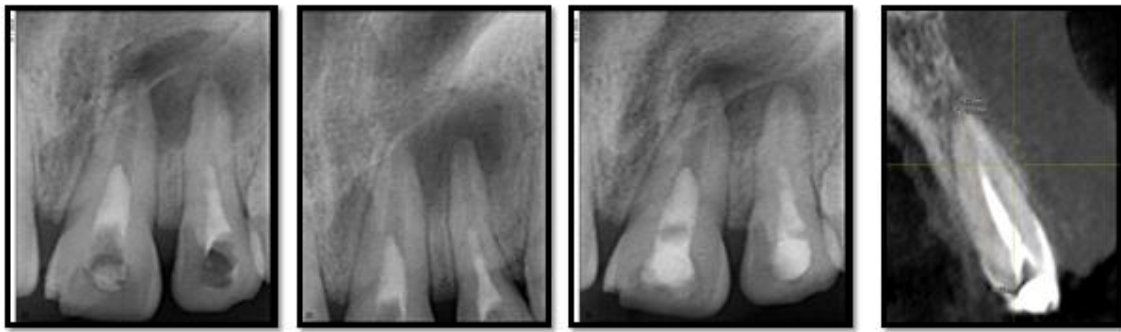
(a,b,c,d): Showing 3rd month, 9th month, 12th month, post-op CBCT respectively for case 2.
